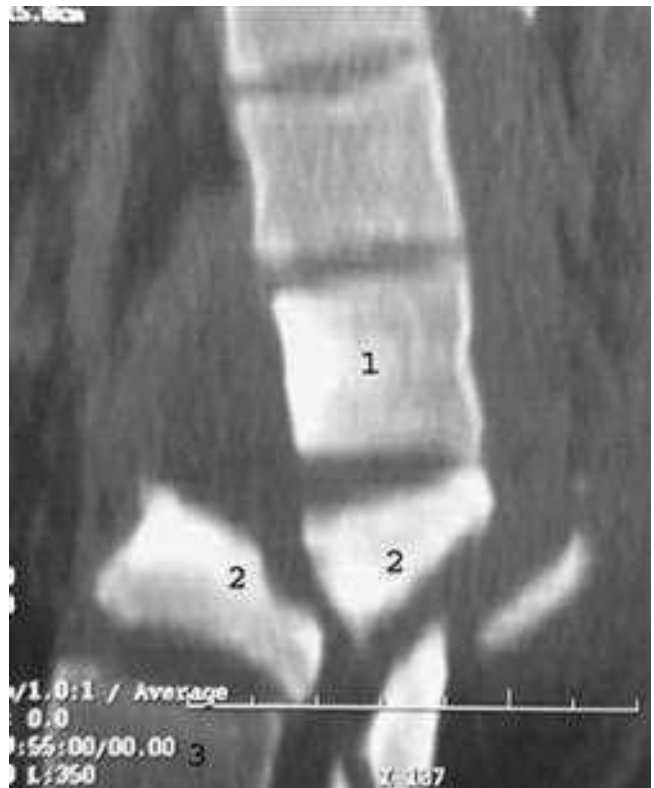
Sagittal reconstruction of an axial fine-slice computed tomography scan through the lumbar spine demonstrating a severe fracture-dislocation through the body of L2.
